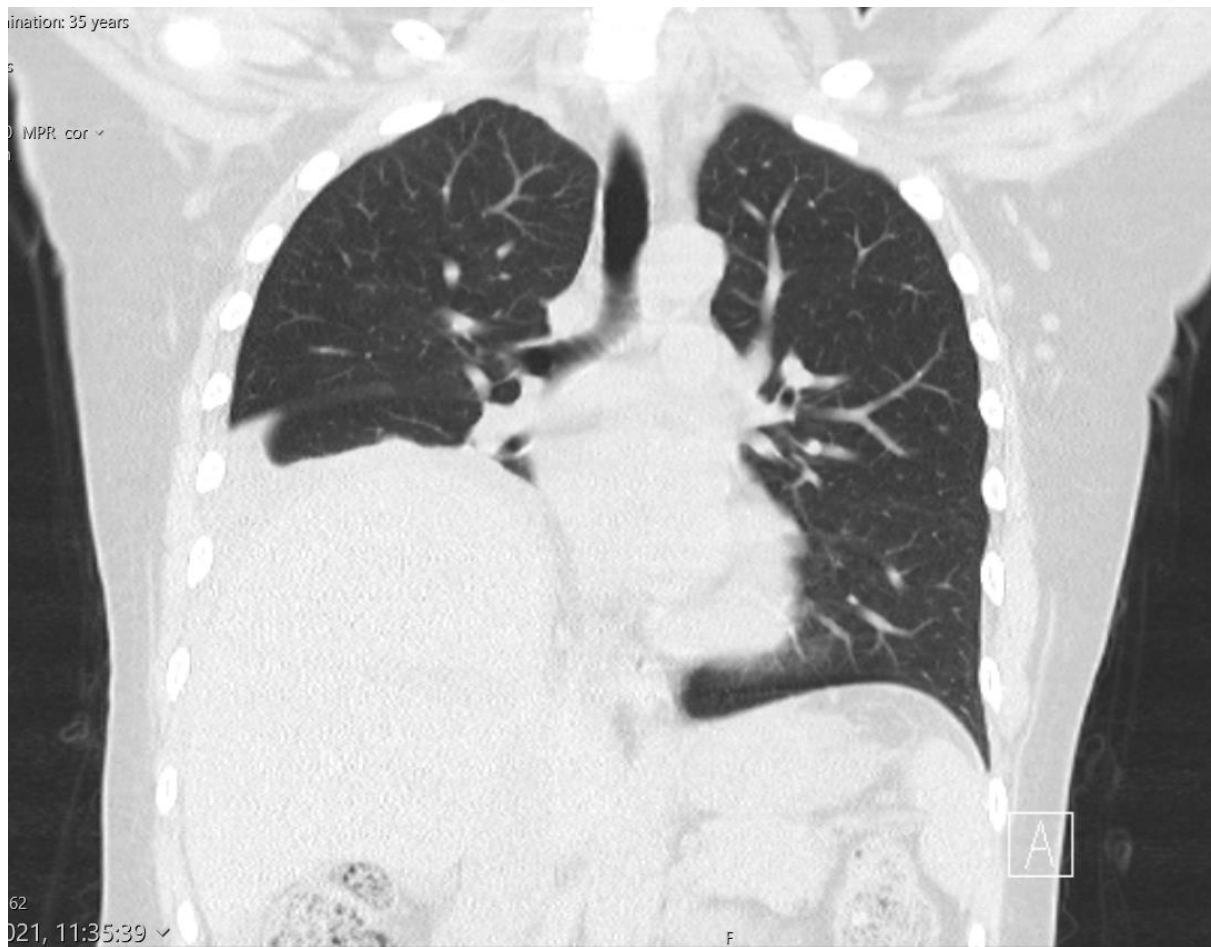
HRCT thorax right pleural effusion and raised hemidiaphragm.
